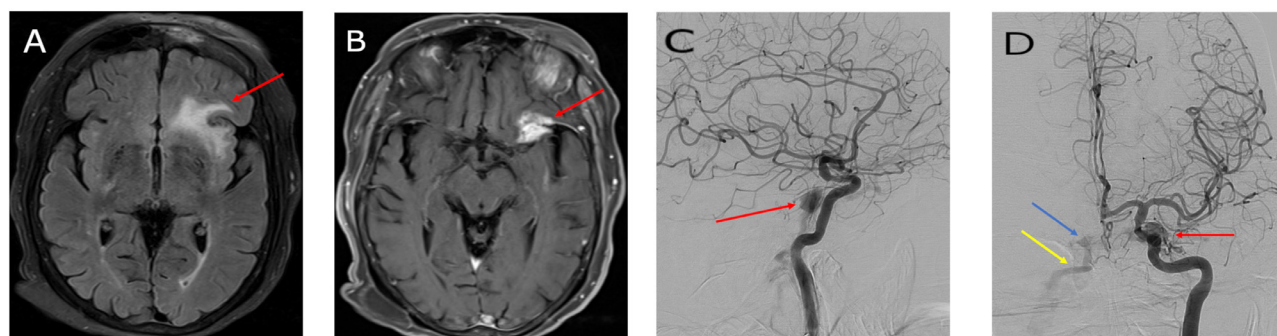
(– A) Axial FLAIR sequence from a brain MRI demonstrates anteroinferior left frontal lobe and left sub-insular edema. (B) Axial T1-weighted post-contrast sequence from a brain MRI demonstrates abnormal enhancement in the anteroinferior left frontal lobe and left sub-insular region. (C) Arterial phase cerebral angiogram of the left ICA in the lateral projection demonstrates early filling of the left cavernous sinus consistent with an indirect CCF. (D) Arterial phase cerebral angiogram of the left ICA in the frontal projection demonstrates early filling of the left cavernous sinus (Red arrow) consistent with an indirect CCF. Note rapid flow across midline into the right cavernous sinus (Blue arrow) and right inferior petrosal sinus (Yellow arrow).
